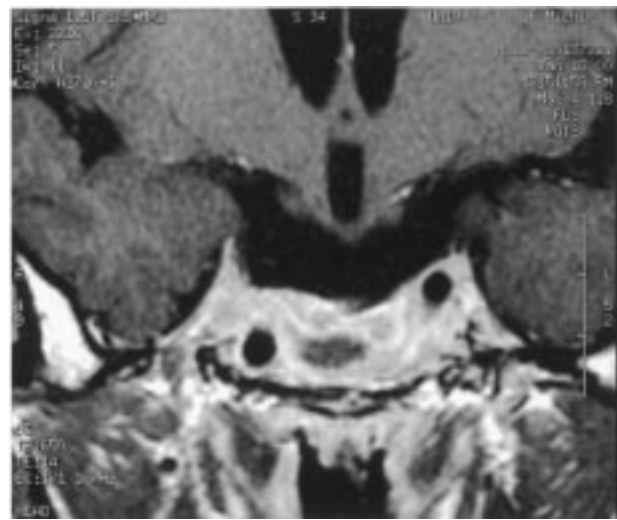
Coronal gadolinium-enhanced T1-weighted pituitary magnetic resonance image after 5 months of pergolide therapy. Significant tumor shrinkage is maintained and the optic chiasm is fully decompressed.
